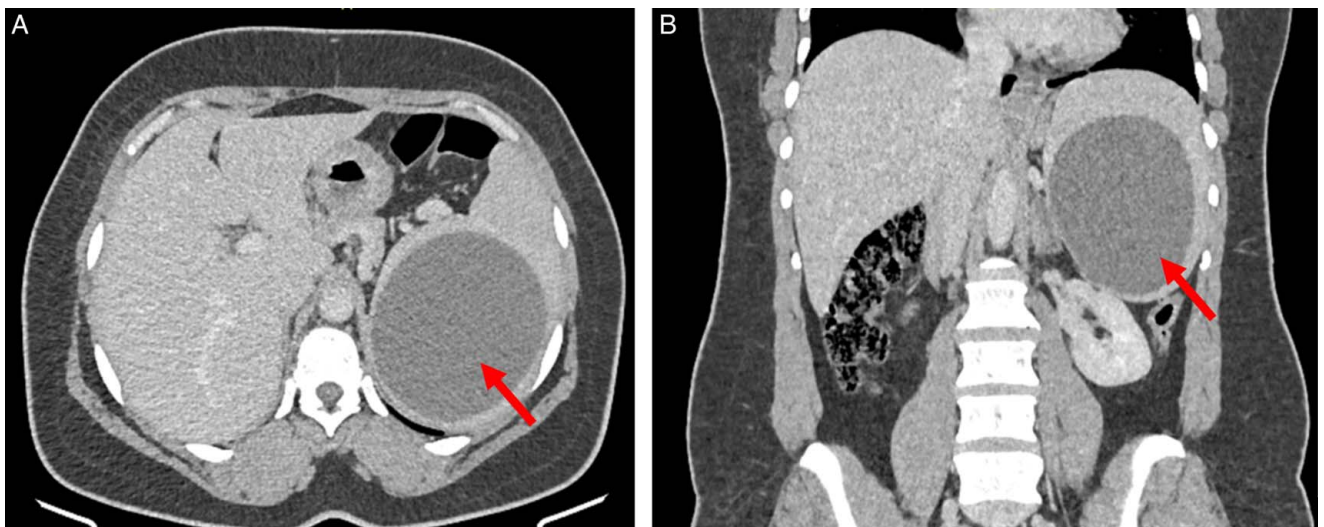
Abdominal CT scan views (A: axial and B: coronal) showing a large splenic unilocular cyst measuring 105×95×117 mm, with thin walls and homogeneous liquid content (red arrow).
